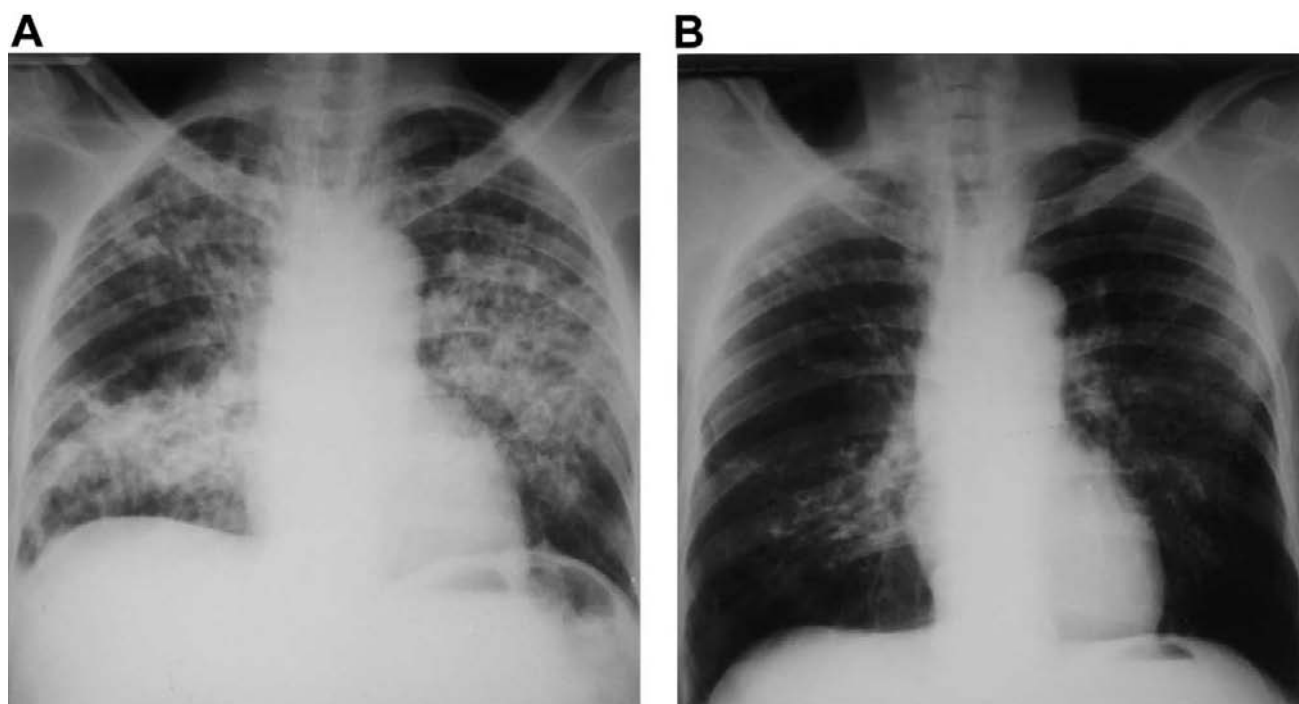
A, Chest radiograph at diagnosis showing severe mixed-type infiltrative lesions in a 65-year-old patient with paracoccidioidomycosis. B, Radiograph for the same patient at the end of the posttherapy follow-up period (12 months) showing extensive fibrosis and basal bullae.
